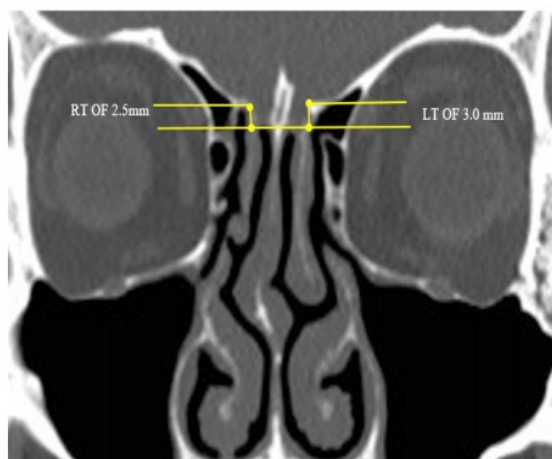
Measurement of olfactory fossa depth on coronal reformatted computed tomographic 1mm thick images (left: Keros I, middle: Keros II and right: Keros III).
